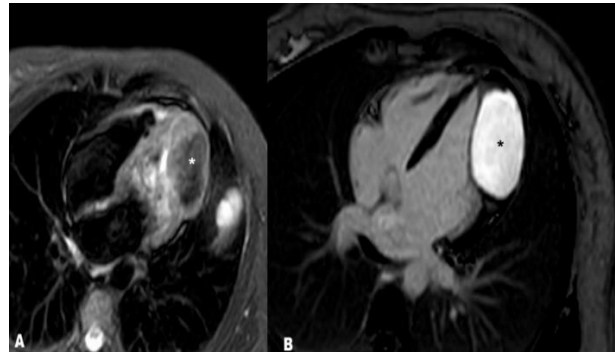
Preoperative cardiac magnetic resonance (CMR) imaging. (A) Short tau inversion recovery (STIR) sequence (four-chamber view) shows low signal intensity on T2-weighted imaging (white asterisk). (B) Phase-sensitive inversion recovery (PSIR) sequence (four-chamber view) demonstrates avid, homogenous late gadolinium enhancement of intramyocardial mass (black asterisk), consistent with fibroma.
